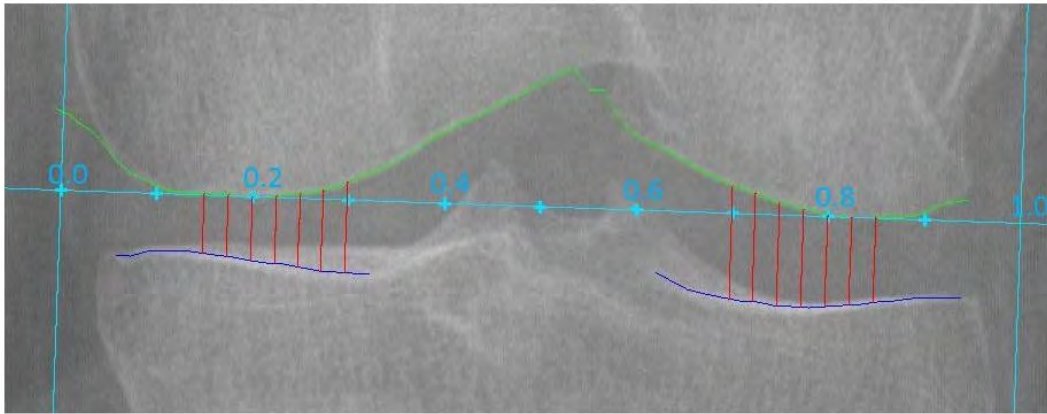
Fixed-location joint space width (JSW) measurements provided by quantitative radiographic OA scores (QROS) software. The variance of fixed-location JSW across the tibiofemoral joint (TF) may reflect degree of bone curvature, asymmetry of cartilage thickness in the TF joint, and/or uneven joint loading.
